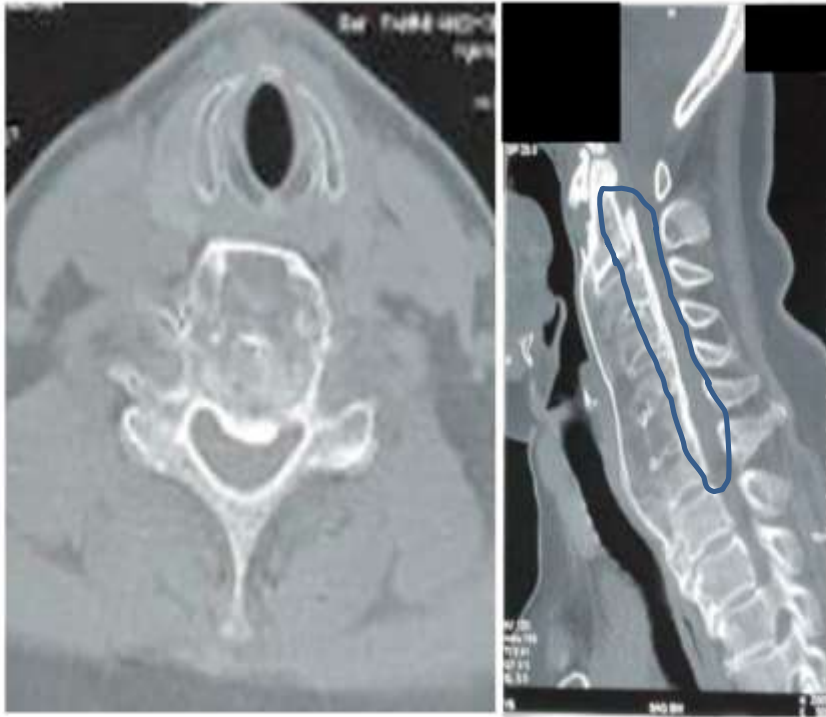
CT Cervical. Axial and sagittal view showed diffuse ossification of the corpus of vertebra cervical 2 to 7 and anterior thickening of the OPLL.
